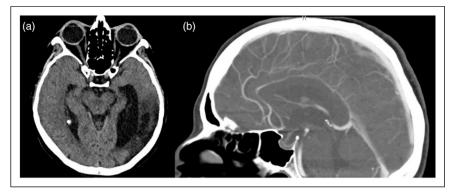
CT (a) and CT angiography (b) 6 months after discharge. (a) Left temporo-parieto-occipital poromalacic areas. (b) Complete thrombosis of the left transverse sinus and partial thrombosis of the left sigmoid and petrosal sinuses.
